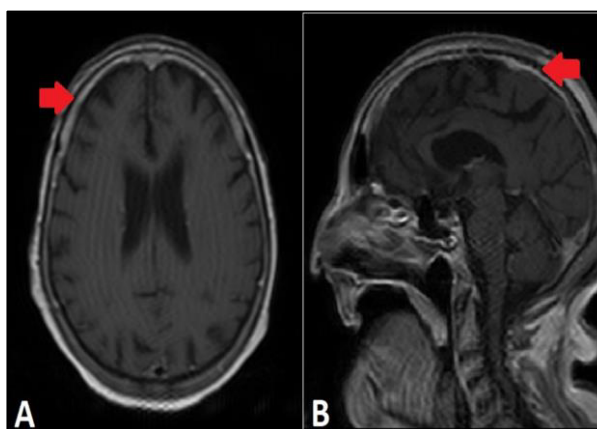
T1 weighted-contrast-enhanced MRI brain showing patchy meningeal enhancement (arrows) on axial (A) and sagittal (B) views
